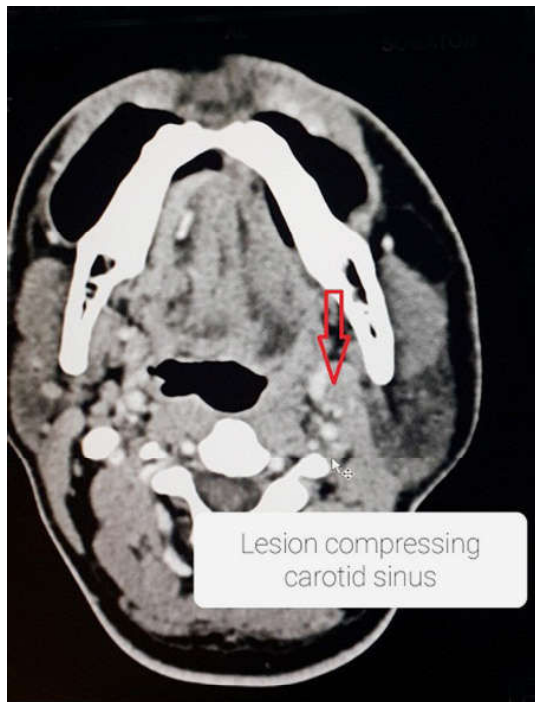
CT Scan film showing mass engulfing the Carotids.
